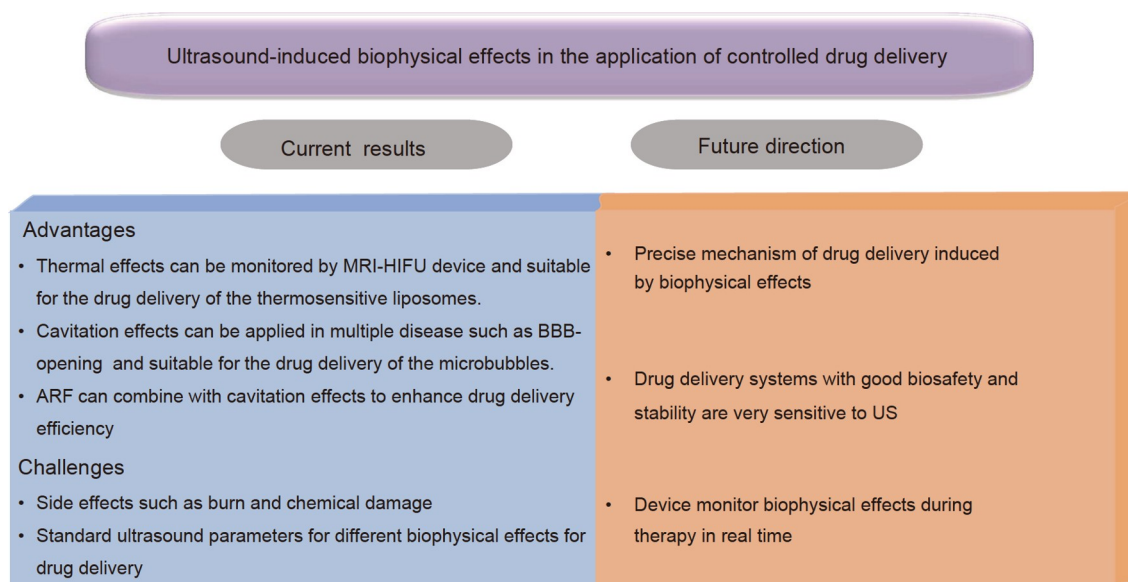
(Color online) Summary of recent advances and future research directions for ultrasound-triggered drug delivery.
